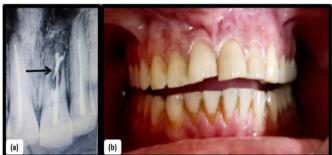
Pre-operative radiograph (a) and Clinical view (b) Arrow shows resorption site.
